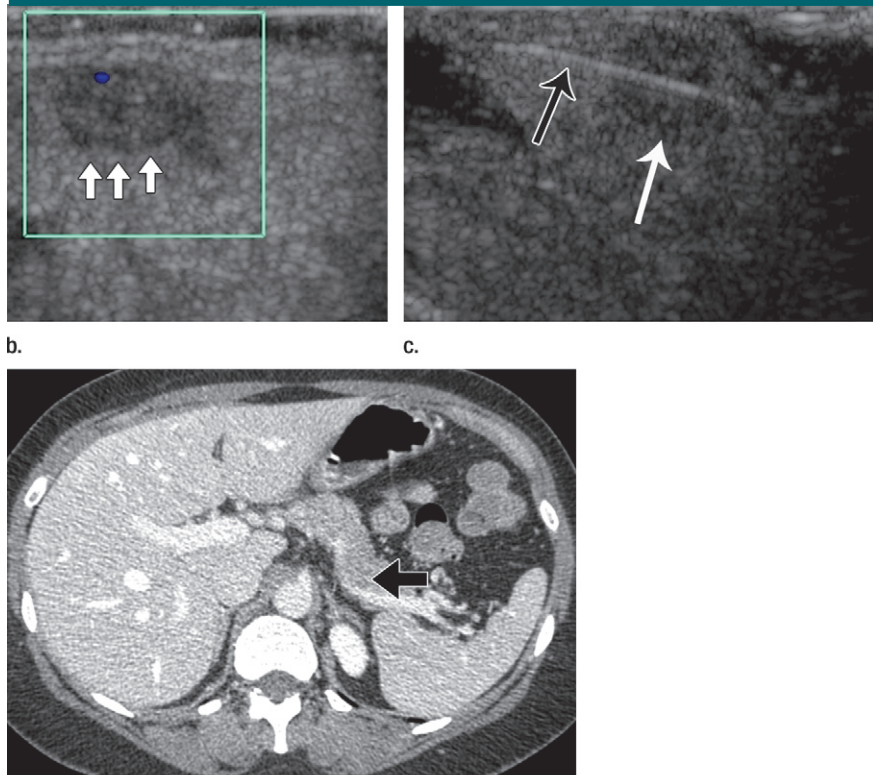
Images in a 50-year-old woman with a strong family history of pancreatic cancer. Intraoperative US was used to localize the lesion and determine the extent of distal pancreatectomy required. (a) CT image shows equivocal hypoenhanced lesion (arrow) that was not amenable to laparoscopic biopsy. (b) No mass could be palpated at laparotomy, but US image confirms presence of 6-mm lesion (arrows). (c) After excision, ex vivo US was used to assist placement of needle (black arrow) through the lesion (white arrow) to allow the pathologist to obtain a frozen section, which demonstrated pancreatic intraepithelial neoplasia. Value score of 3.
